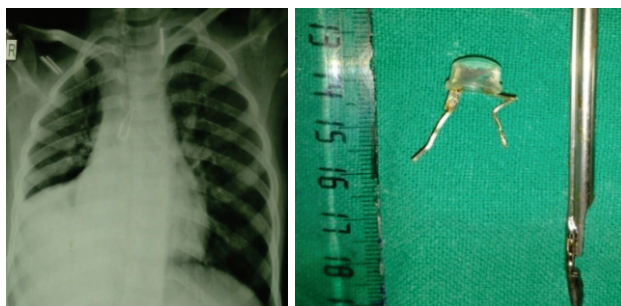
X-ray chest showing FB in right bronchus
